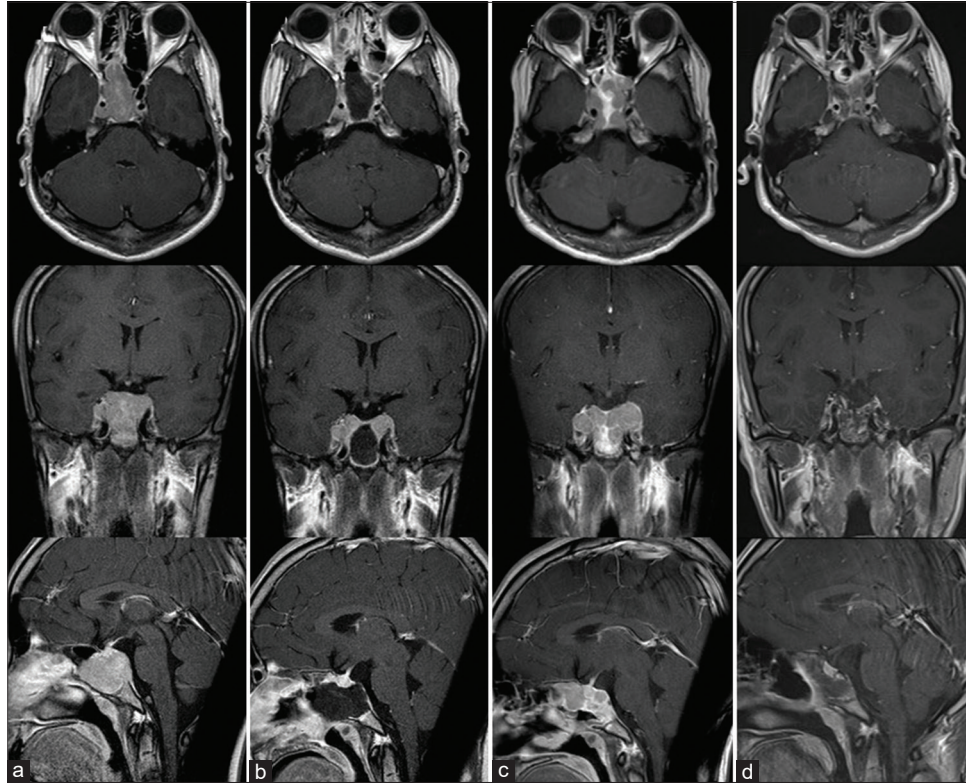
Axial, coronal, and sagittal views of gadolinium-enhanced T1-weighted MRI of a patient with giant cell tumor of sphenoid bone at preoperative (a), postoperative (b), 3 months after the operation (c), and 3 months after the initiation of denosumab treatment (d).
